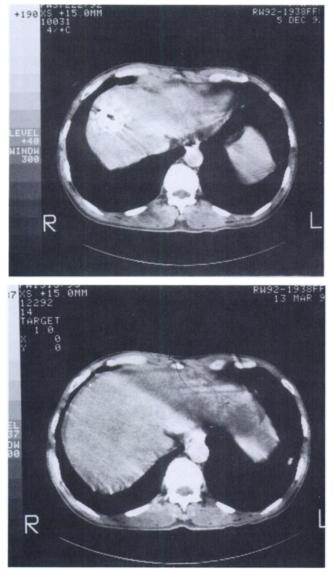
(A) CT scan of the liver of Patient 18 with a 4.5 cm HCC in the right lobe before ¹³¹I-L treatment. (B) CT scan of the liver of the same patient performed 2 mo after a 1.85-GBq ¹³¹I-L treatment. The AFP decreased to less than 5% of the pre-treatment level.
